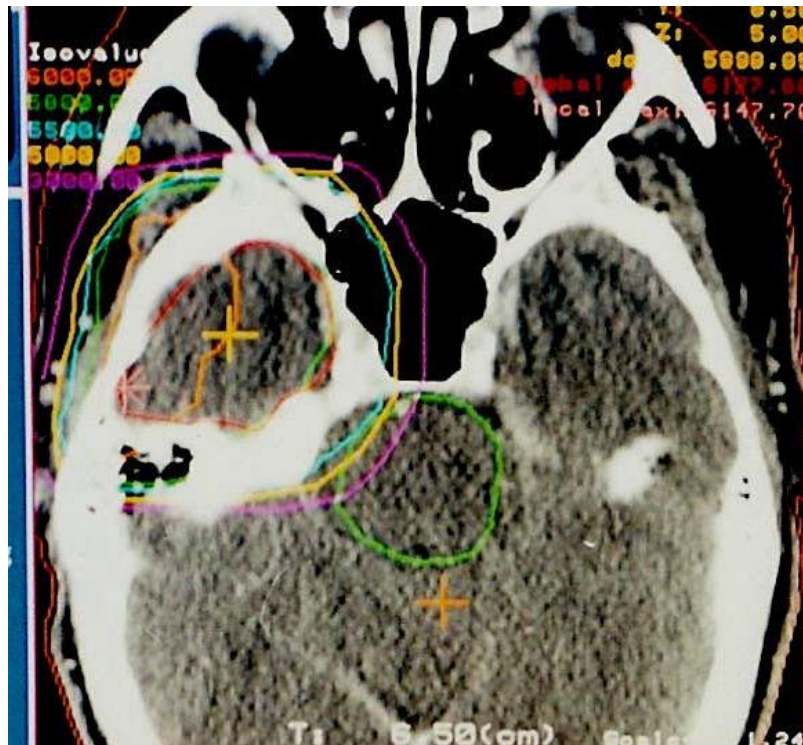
Axial CT slice at isocenter with CTV and isodose contours superimposed. Show at least the 6420, 6000, 5800, 5500, 5000, and 3000 cGy contours.
